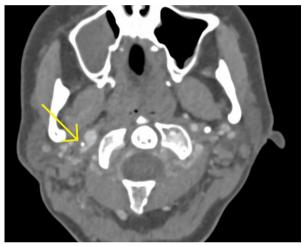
Axial reconstruction of angiography CT scan showing the tip of the styloid process compressing the right internal carotid artery
